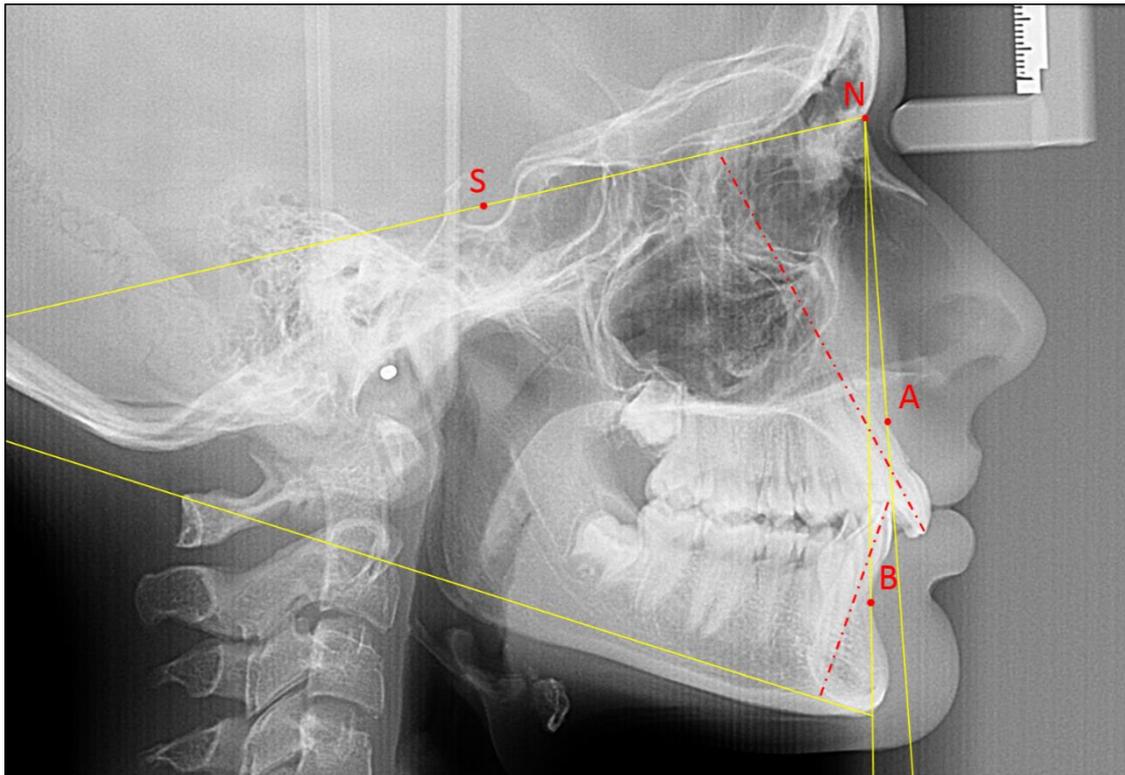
Later cephalometric radiograph with location of the cephalometric landmarks and reference lines.
